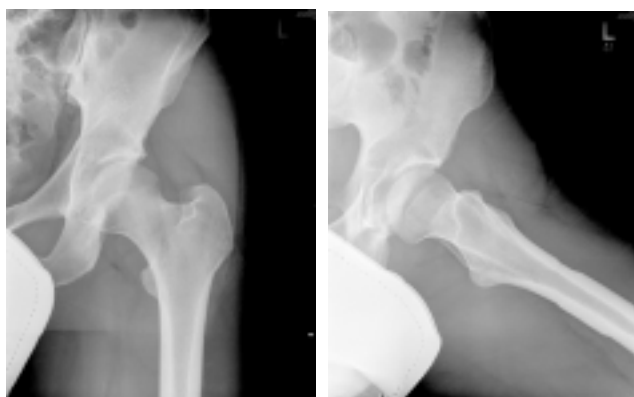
AP and lateral radiographs of the left hip were obtained. No plain film osseous or articular abnormalities are identified.
